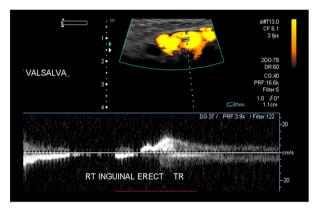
Round ligament varicosities show a venous flow waveform demonstrated with power Doppler/duplex imaging.
